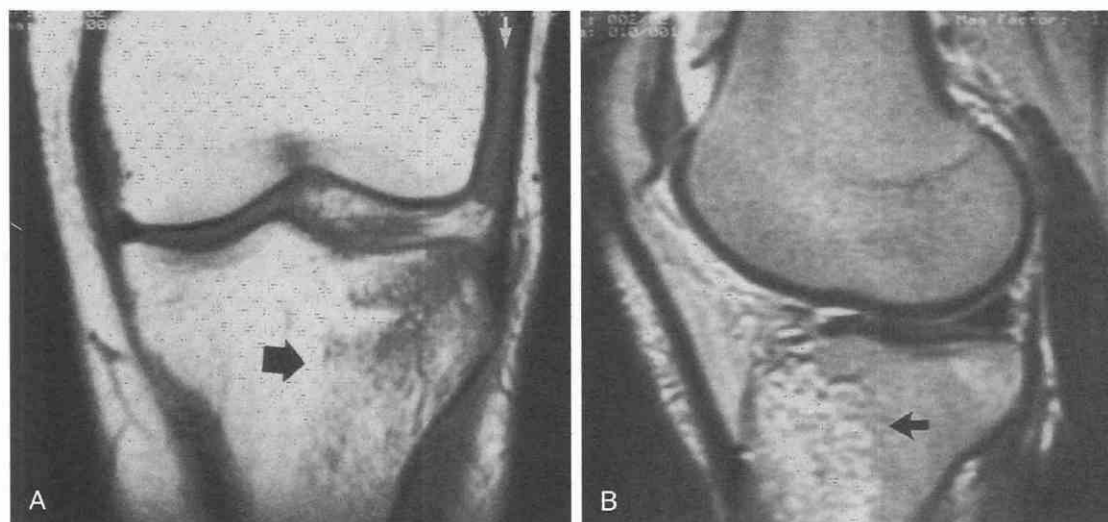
Bone bruise. A, Coronal T1-weighted image shows an ill-defined, subchondral, reticulated or stellate region of low signal intensity beneath the lateral tibial plateau (black arrow). Fluid is seen at the suprapatellar bursa, at the lateral gutter (white arrow). B, Sagittal T2-weighted image shows increased signal intensity indicative of edema or hemorrhage (arrow).
